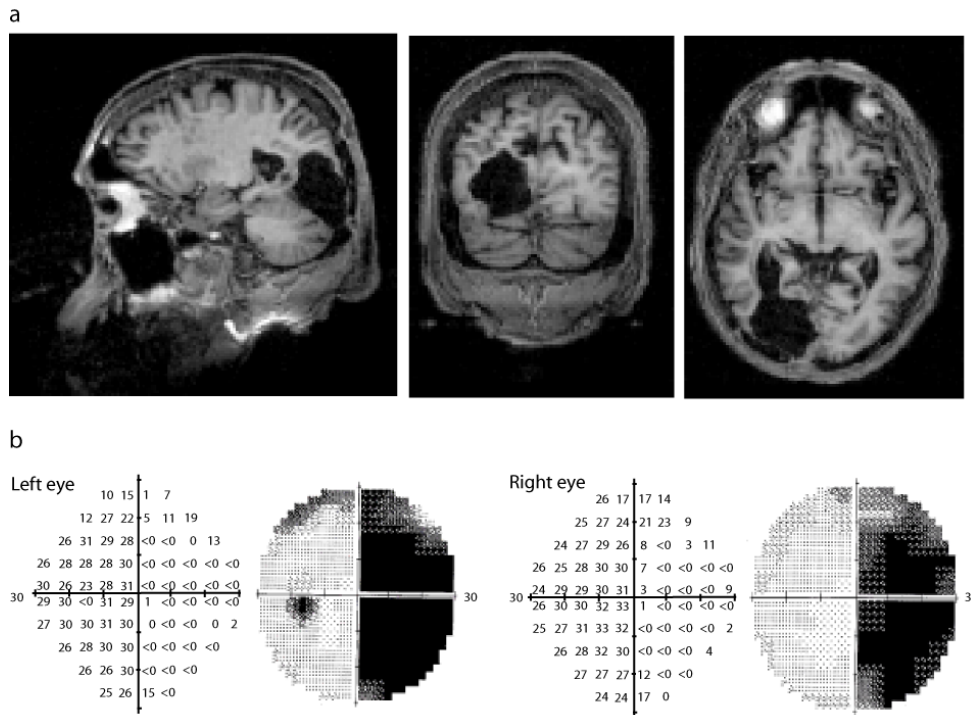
(a) Anatomical location of the lesion. Three sections (sagittal, coronal and axial) are shown through POV's T1-weighted MRI. A large cystic lesion is seen in the left occipital lobe which is in communication with the left lateral ventricle, involves most of the occipital lobe and extends anteriorly to involve parts of the inferior temporal lobe. In the coronal and axial sections, the left hemisphere is shown on the left. (b) Visual Field testing. Humphrey Field Analyser plots for POV measured at the time of testing on Humphrey Visual Field Analyser, 30-2 Full Threshold protocol, demonstrating a large right homonymous hemianopia. Locations marked as '<0' represent locations where the brightest stimulus did not elicit a response. These areas are marked in black. Note that fields are presented to 30 degrees eccentricity. POV has residual vision on perimetry beyond 30 degrees but the stimulus was at 4.5 degrees eccentricity and the field of view in the MRI scanner is approximately 20 degrees eccentricity.
